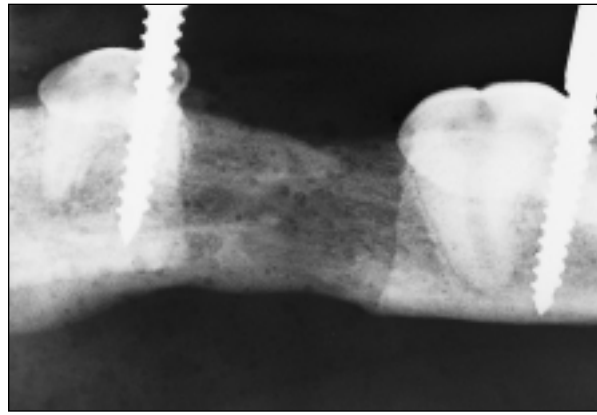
Axial radiograph taken 3 weeks after the completion of distraction. Parallel columns of bone extending from the edges of the site could be seen.
